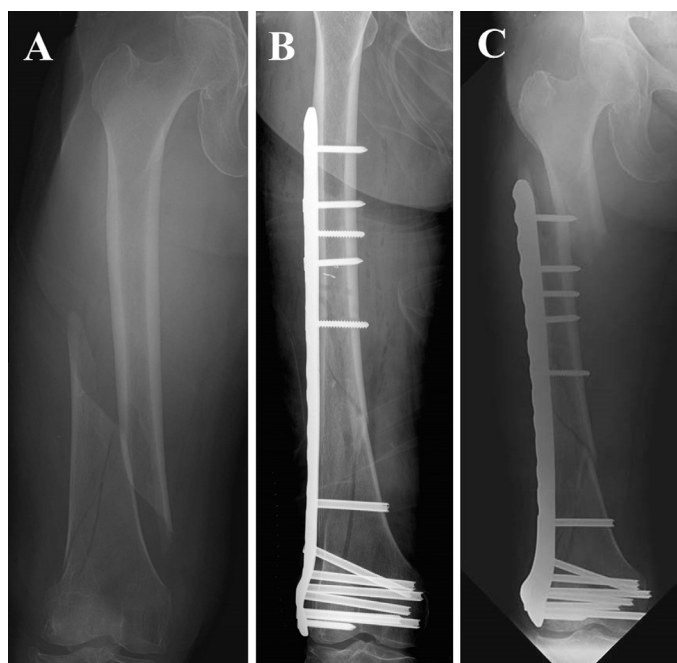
(A) Radiograph of a distal femur fracture after a ground-level fall. (B) Postoperative anteroposterior radiograph after closed reduction and minimally invasive locked plating. (C) 6-week postoperative radiograph showing a stress riser fracture around the outermost locking screw after fall down injury.
